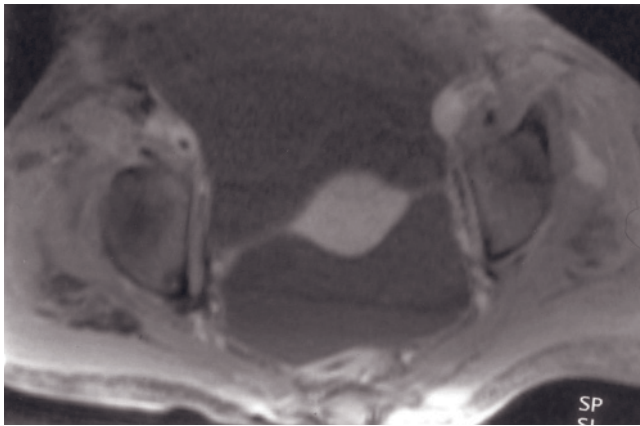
Postsurgical intraperitoneal air and fluid. Transverse T2-weighted SS-ETSE (a) and SGE (b) images in a patient with a recent history of surgery demonstrate the presence of pneumoperitoneum and ascites. Note that air is invariably located along the most elevated surface in structures.
